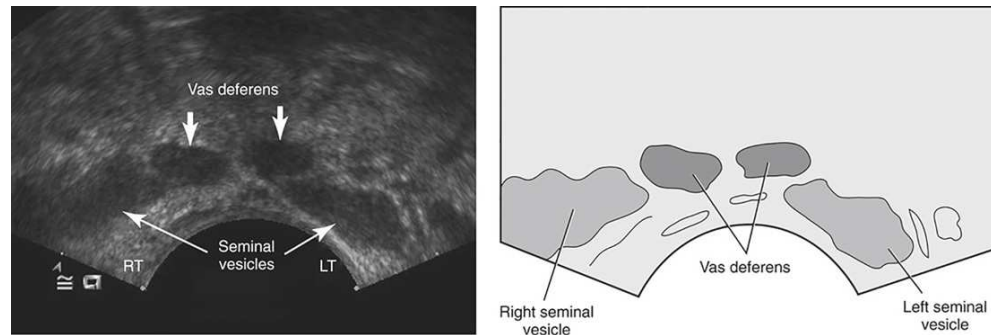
Transrectal ultrasound image of normal seminal vesicles (long axis). From Curry R, Tempkin B. *Sonography: Introduction to normal structure and function*. ed 4. St. Louis: Elsevier; 2016.
